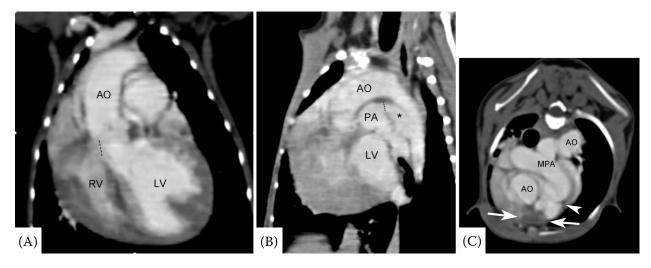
The contrast cardiac CT. (A) In the dorsal reformatted image, a ventricular septal defect (dotted line), overriding aorta, and right ventricular hypertrophy can be detected. (B) The conical patent ductus arteriosus (asterisk) is seen and the ductal ostium diameter is 3.8 mm (dotted line). (C) The transverse image shows a region not filled with contrast medium within the right ventricular outflow tract (arrows) immediately below the pulmonary valve (arrow head)
